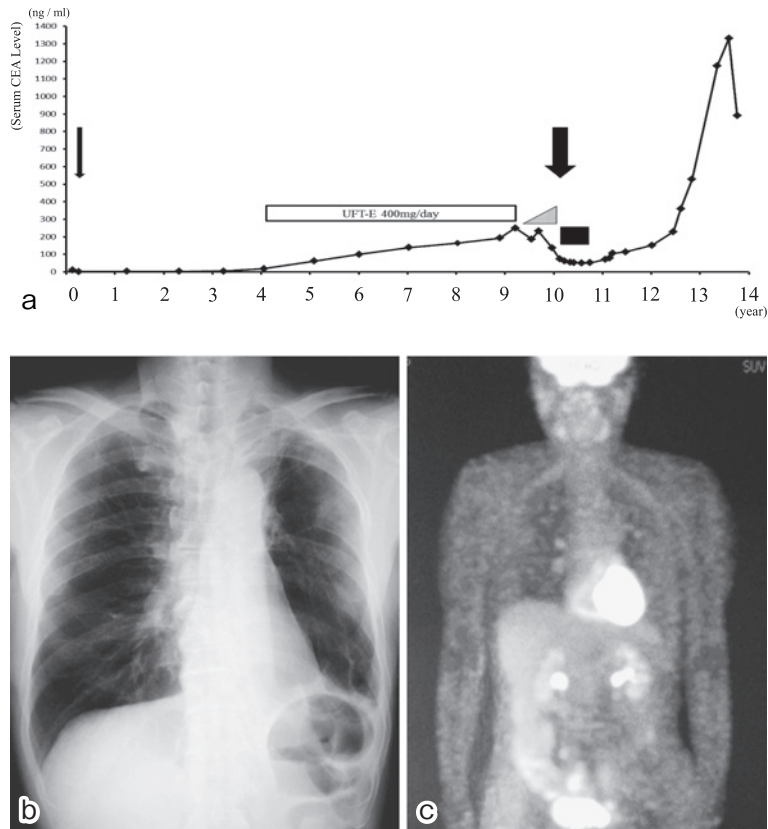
There was no evidence of metastasis or other malignancy, except for an elevated serum level of carcinoembryonic antigen (CEA) (a) The CEA level remained elevated for 5 years. The thin arrow indicates the day of the first surgery (left upper lobectomy). The thick arrow indicates the day of video-assisted thoracoscopic surgery (VATS) biopsy (second surgery). The triangle indicates pleural effusion. The solid square indicates the period of platinum doublet chemotherapy (Carboplatin+Paclitaxel). (b) Chest radiograph obtained 10 months before biopsy. (c) Positron emission tomography (PET) obtained 4 months before biopsy.
